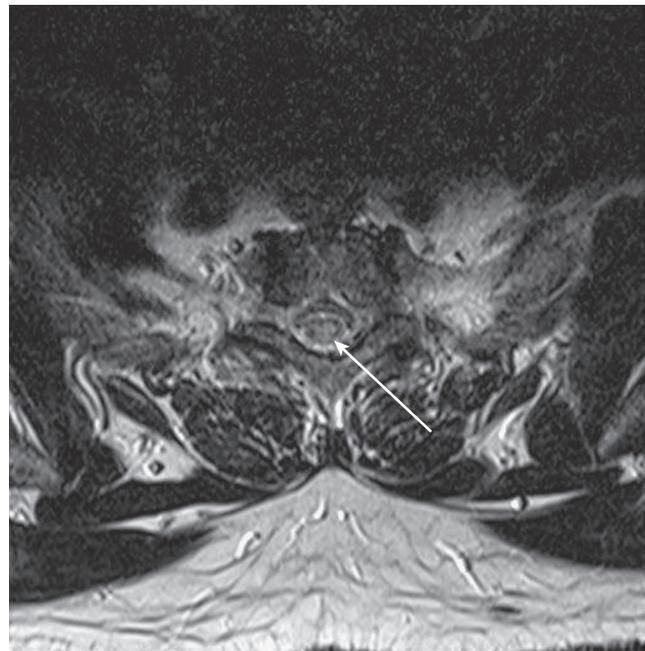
Myelitis: T2-weighted magnetic resonance image of the axial cervical spine showing lesion across most of the spinal cord (arrow).
